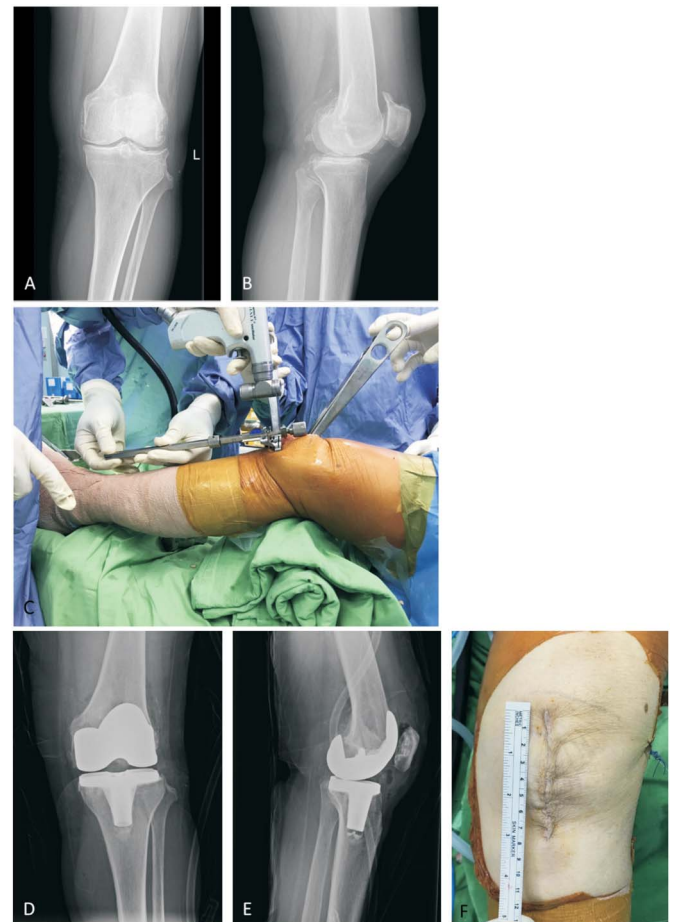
Case demonstration. A and B, pre-operative AP and lateral knee radiographs. C, cutting tibia with knee in semi-extended position. D and E, post-operative radiographs. F, wound size was 8 cm (3.1 inches) in this case.
